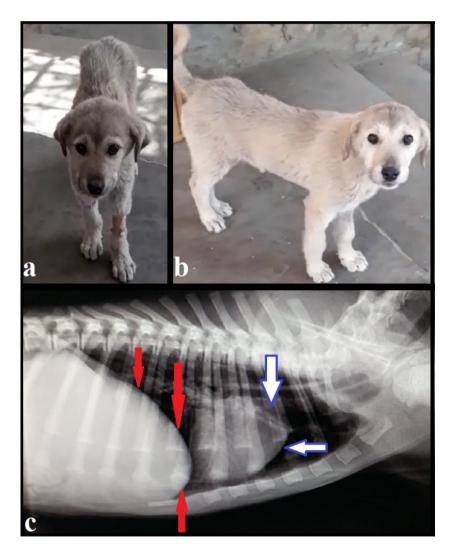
Postoperative 15th day (a) and 30th day (b) image of the patient, postoperative 15th day thorax radiograph of the patient (c), diaphragm line (red arrows), heart (blue-white arrows).
